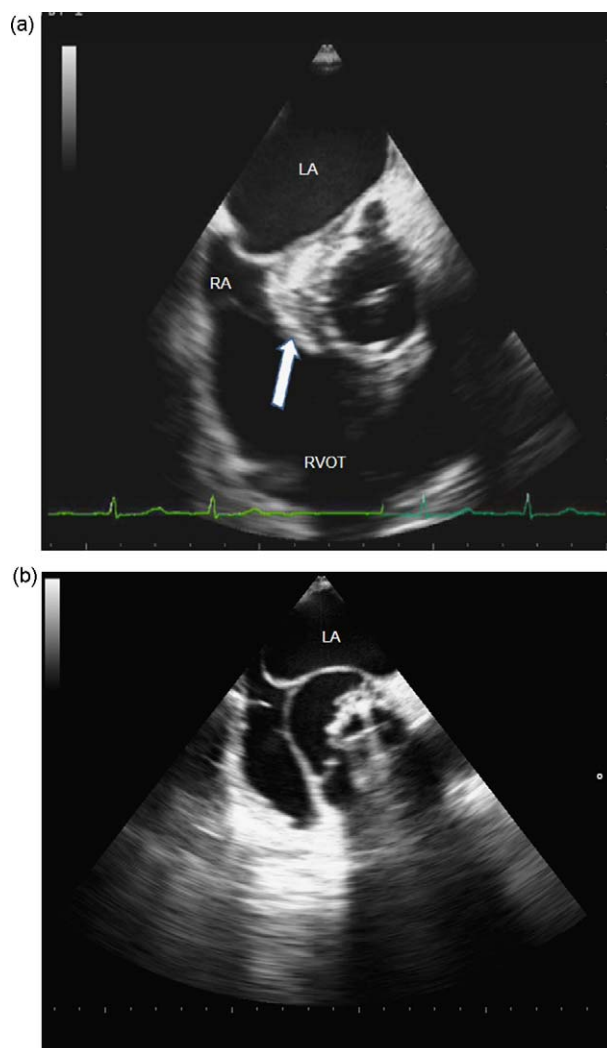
(a) Transesophageal short-axis view of the prosthetic aortic valve. Note periaortic heterogeneous hyperechoic thickening (arrow), which was initially considered as periaortic abscess. (b) Transesophageal short-axis view of the prosthetic aortic valve after 6 weeks of antimicrobial therapy. Former hyperechoic area around the prosthetic valve is replaced by a clear blood-filled sac. LA, left atrium; RA, right atrium. RVOT, right ventricular outflow tract.
